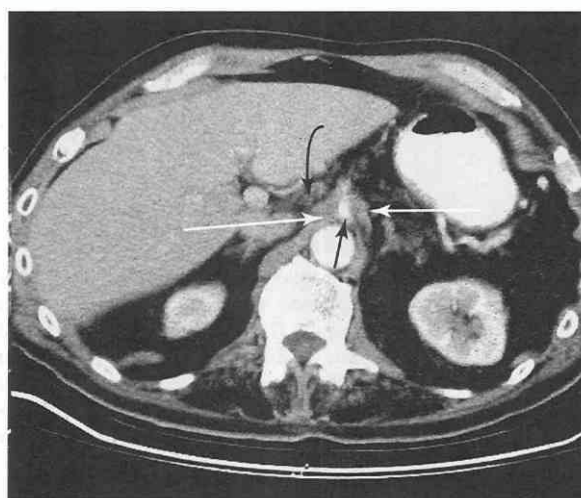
Axial CT scan shows encasement (horizontal arrows) of the celiac artery (vertical arrow). Small lymph node is noted in the porta hepatis region (curved arrow).
